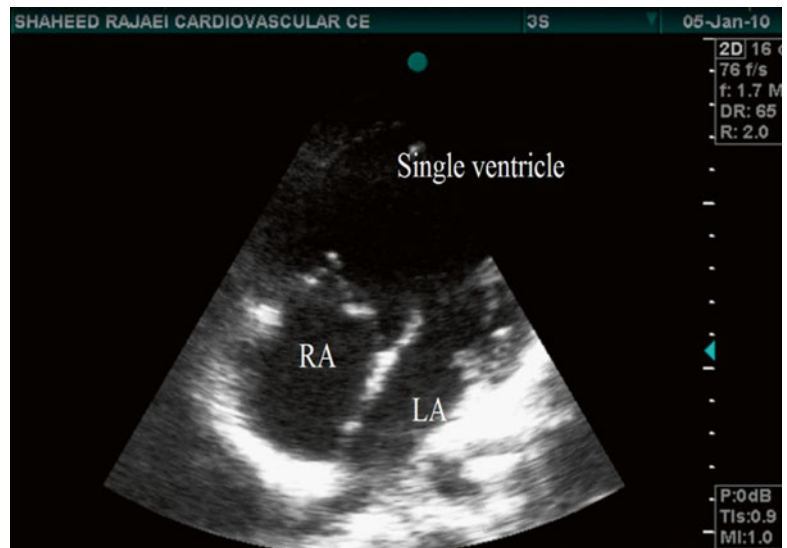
Transthoracic echocardiography in four-chamber view, showing a double-inlet left ventricle (DILV). *RA* right atrium, *LA* left atrium
